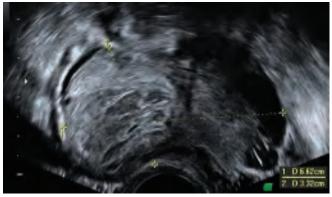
Transvaginal ultrasound of a thickened tube filled with echogenic fluid (pus)
